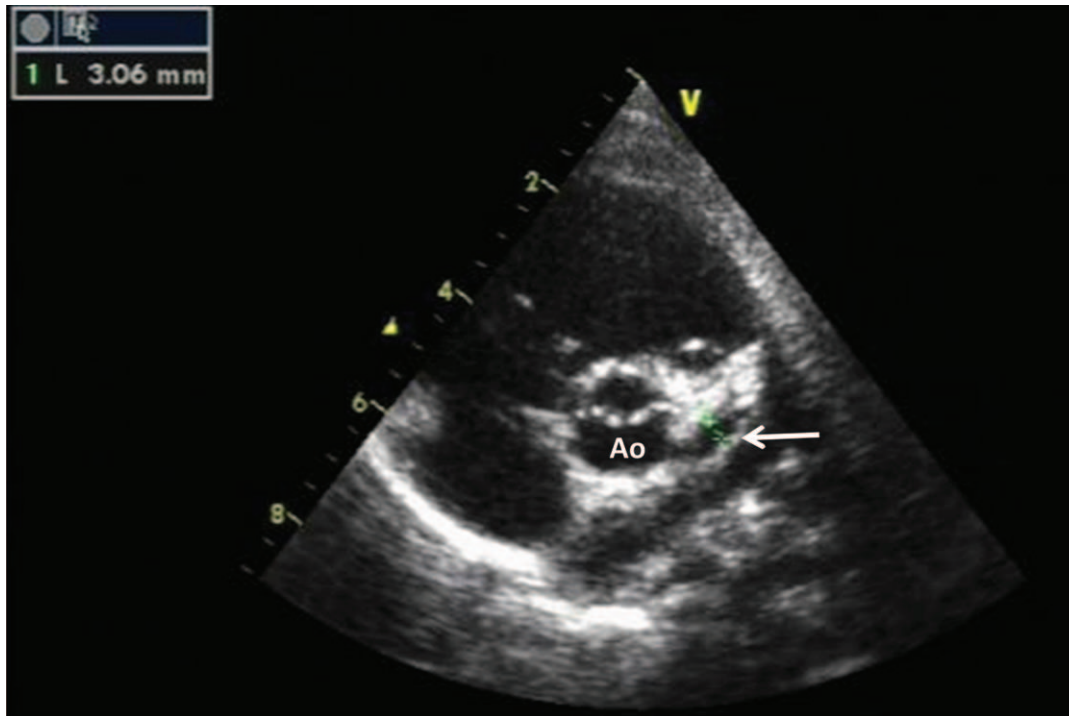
Parasternal short axis echocardiographic image showing dilatation (arrows) in left coronary artery. Ao=aortic root.
